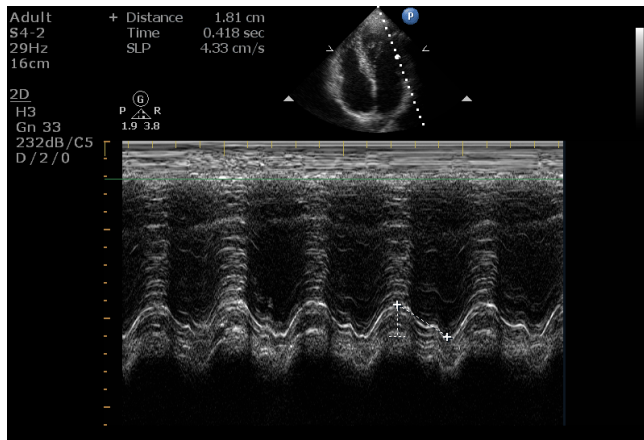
Ultrasound image of MAPSE measurement
